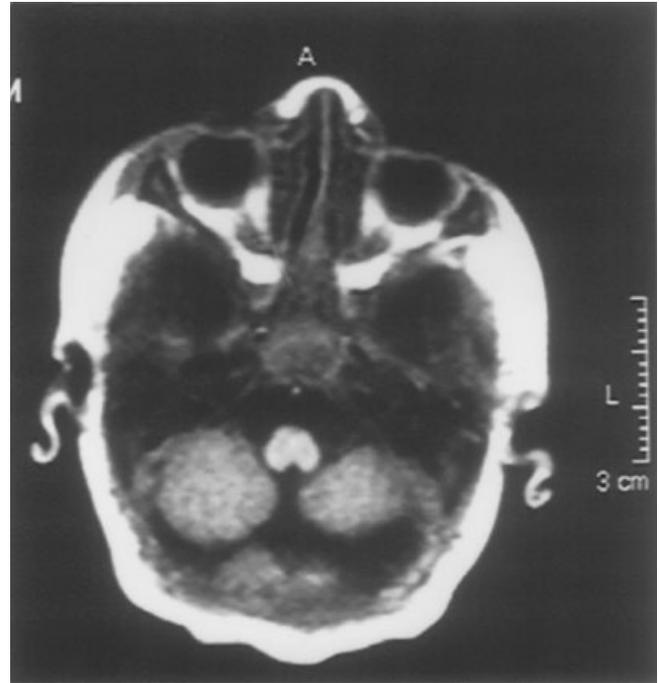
Patient 2: MRI showing extreme atrophy of the brainstem.
